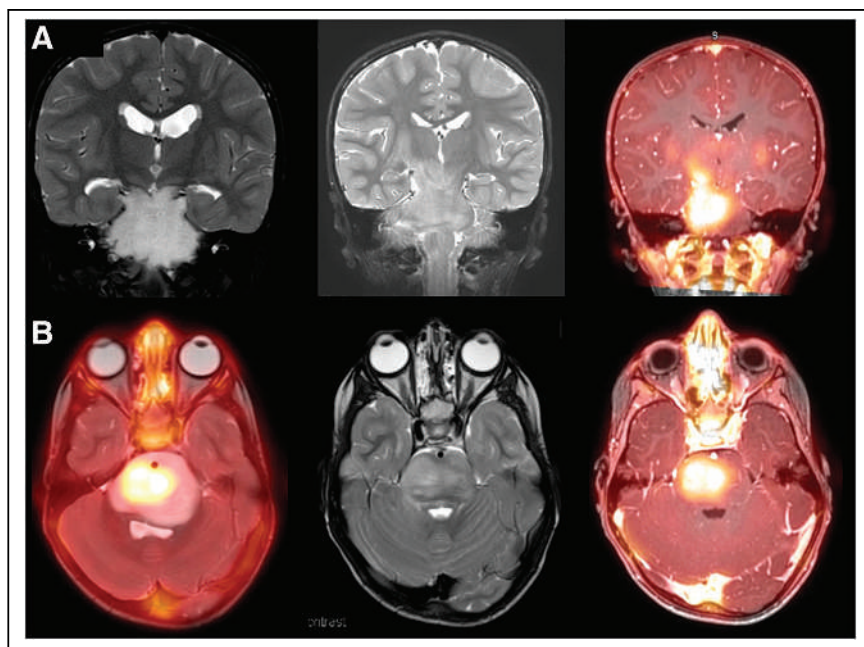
Intense ^{18}F -DOPA uptake in recurrent diffuse intrinsic pontine glioma showing better tumor delineation of true tumor boundaries than on the MRI alone and showing that intensity of uptake is likely a prognostic parameter. (A) From left to right: coronal T2-weighted fat-saturated initial, coronal T2-weighted fat-saturated 9-mo follow-up, and coronal ^{18}F -DOPA 9-mo follow-up PET/MR images. (B) From left to right: axial ^{18}F -DOPA PET fused to initial MR, axial T2-weighted fat-saturated 9-mo follow-up MR, and axial ^{18}F -DOPA 9-mo follow-up PET/MR images.
